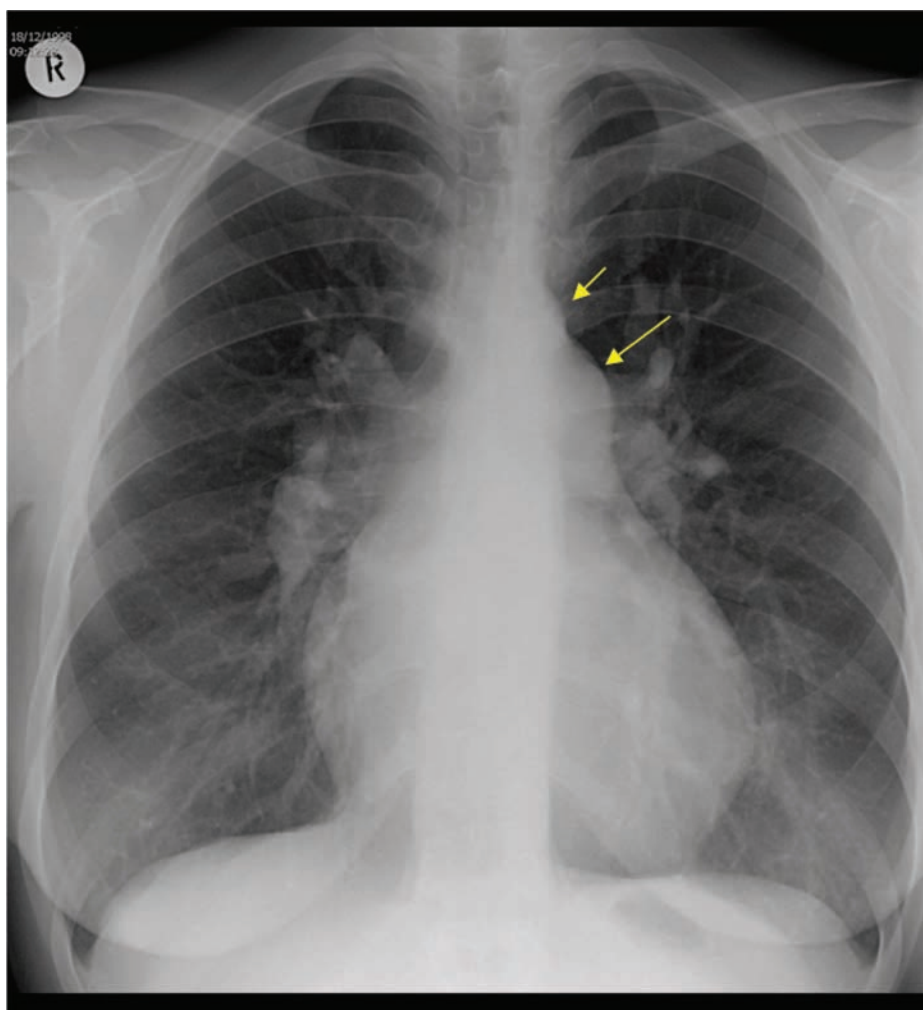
Chest x-ray of a patient with ASD and PH. The main pulmonary artery (long arrow) and its main branches are enlarged, and the peripheral pulmonary vessels by comparison are “pruned.” The heart is enlarged and the shape suggests right heart enlargement. The aortic knuckle (short arrow) is small—a feature typical of ASD.
